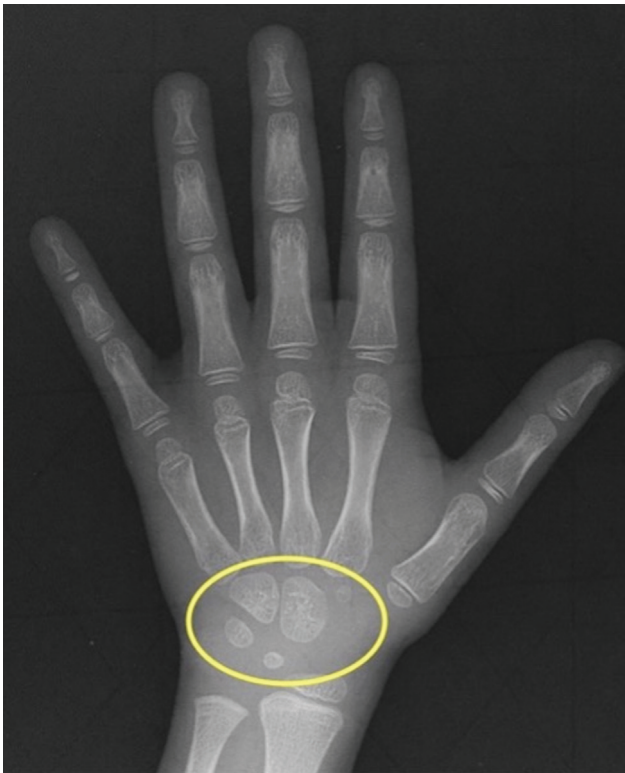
Anteroposterior view of wrist radiograph showing five carpal bones (yellow circle) indicating approximate age more than 5 years.
